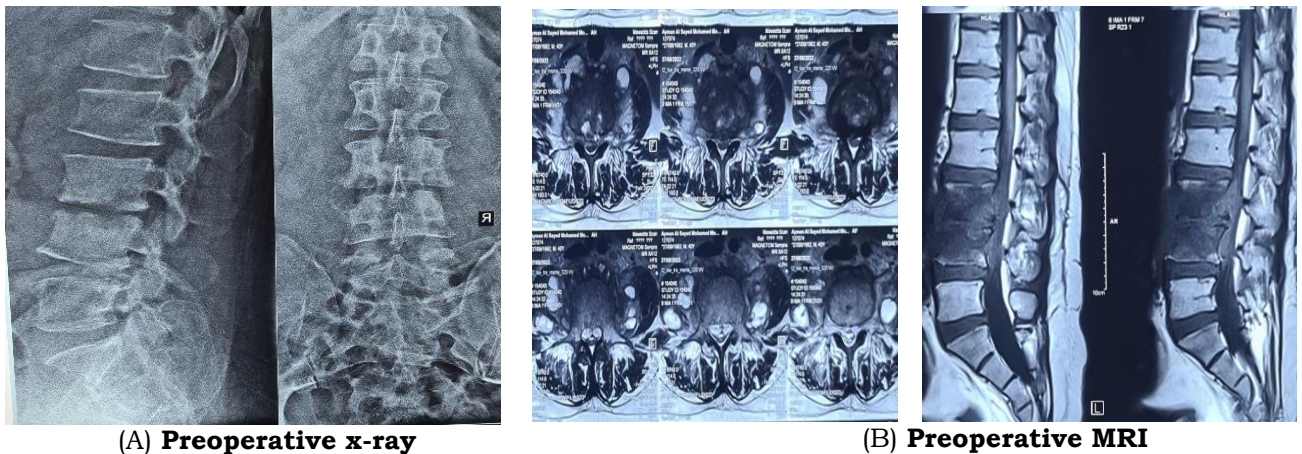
(A)Preoperative x ray and (B)Preoperative MRI
